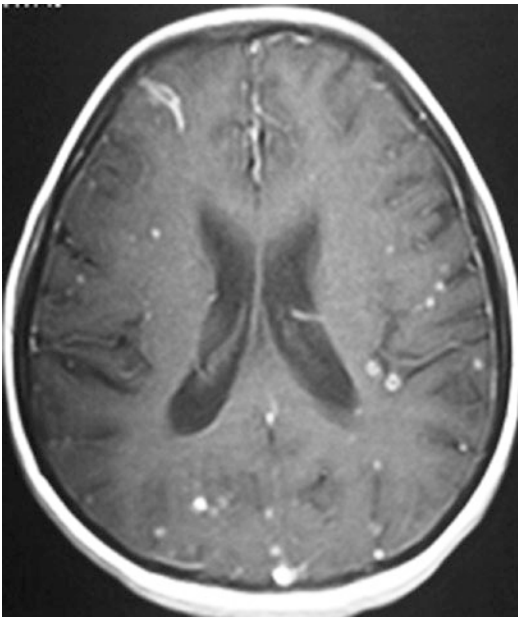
Miliary brain TB. Axial post-contrast T1-weighted image shows numerous bilateral tiny enhancing nodules. This young female patient presented with chronic cough, headache, dizziness, nausea, and vomiting
